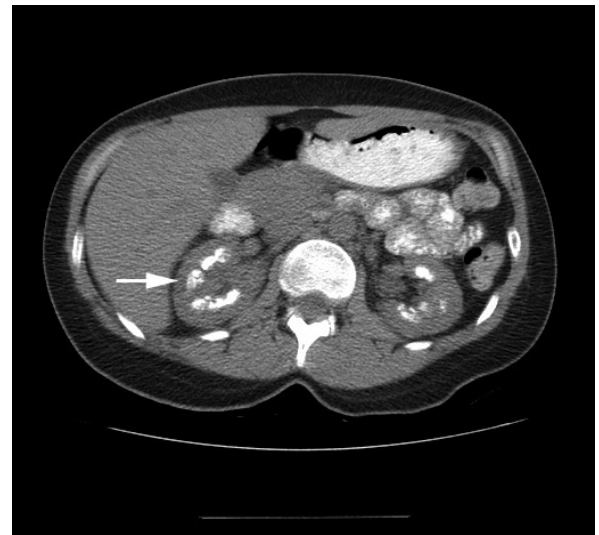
Computed tomographic urogram (precontrast) axial view demonstrating clusters of pyramidal medullary calcification (arrow), characteristic for medullary sponge kidney.
